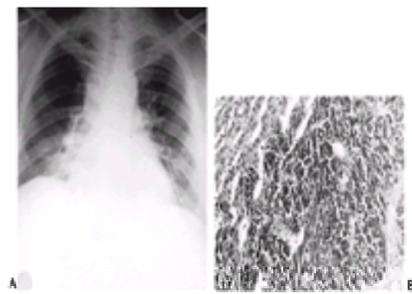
(A) Chest roentgenogram showing an area of increased density along the right cardiac border. The patient was a 34-year-old man with truncal obesity, edema, hypertension, hypokalemic alkalosis, polycythemia, and the typical urinary steroid values of Cushing's syndrome. (B) A liver biopsy was obtained at abdominal exploration. A large nest of anaplastic carcinoma cells metastatic from the lung is seen adjacent to cords of liver cells ($\times 450$).
